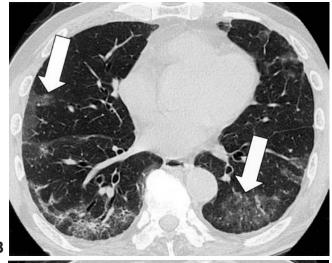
Representative HRCT image. (A) reticular opacity, (B) groundglass attenuation, and (C) consolidation-dominant pattern in patients with DM. (D) Typical presentation of subpleural band.
